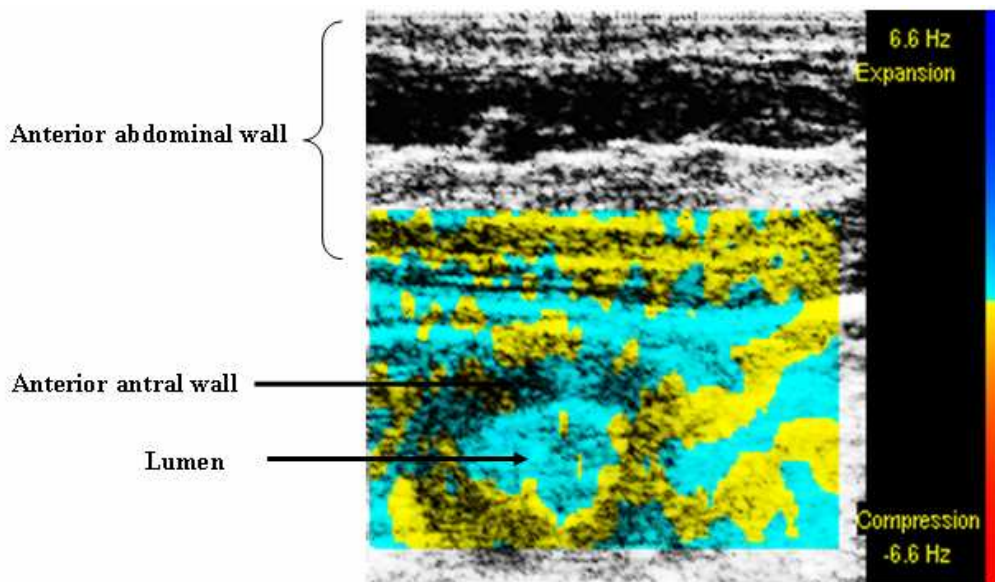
Doppler colour coding of SRI in the human antrum. A turquoise to blue colour indicates positive strain and yellow to red colour indicates negative strain (right margin).
